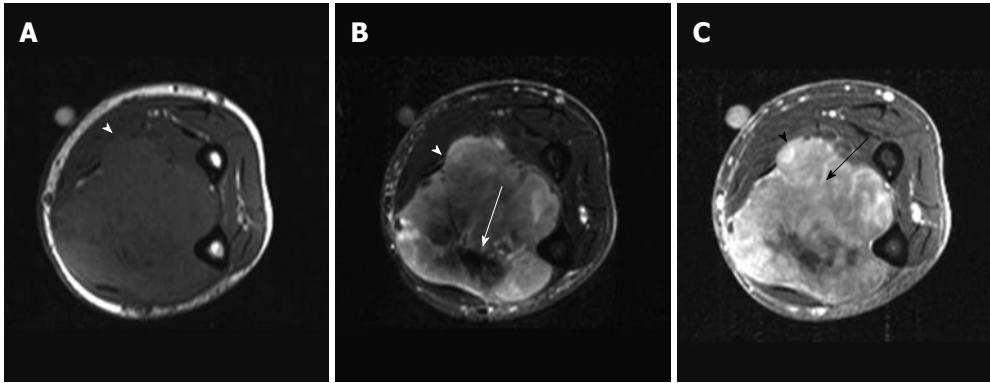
Malignant fibrous histiocytoma. A: Axial T1-weighted MR image of the forearm shows a soft-tissue tumor (arrowhead) with a relatively well-defined margin. No invasion to the adjacent radius or ulna was noted; B: Axial T2-weighted MR image shows heterogeneous signal intensity of the tumor mass (arrowhead), with an area of low signal intensity (arrow), suggesting fibrosis; C: Axial gadolinium-enhanced T1-weighted image with fat saturation shows enhancement of the parenchymal tissue (arrow) of the tumor mass (arrowhead), corresponding to the hypervascular part of the tumor. MR: Magnetic resonance.
